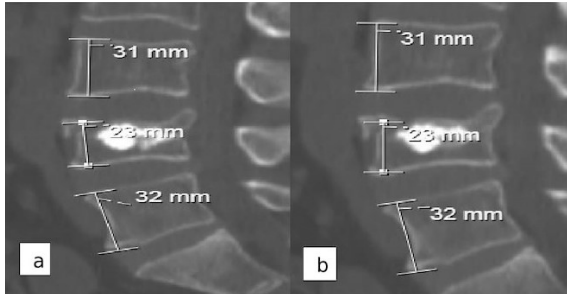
Sagittal plan CT scan of the patient undergoing 3 ml of polymethylmethacrylate;
